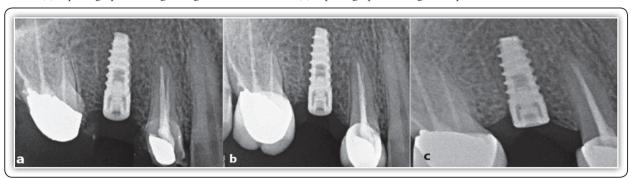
Postoperative periapical radiograph showing (a) After 4 months. (b) After 6 months(c) After 9 months.
